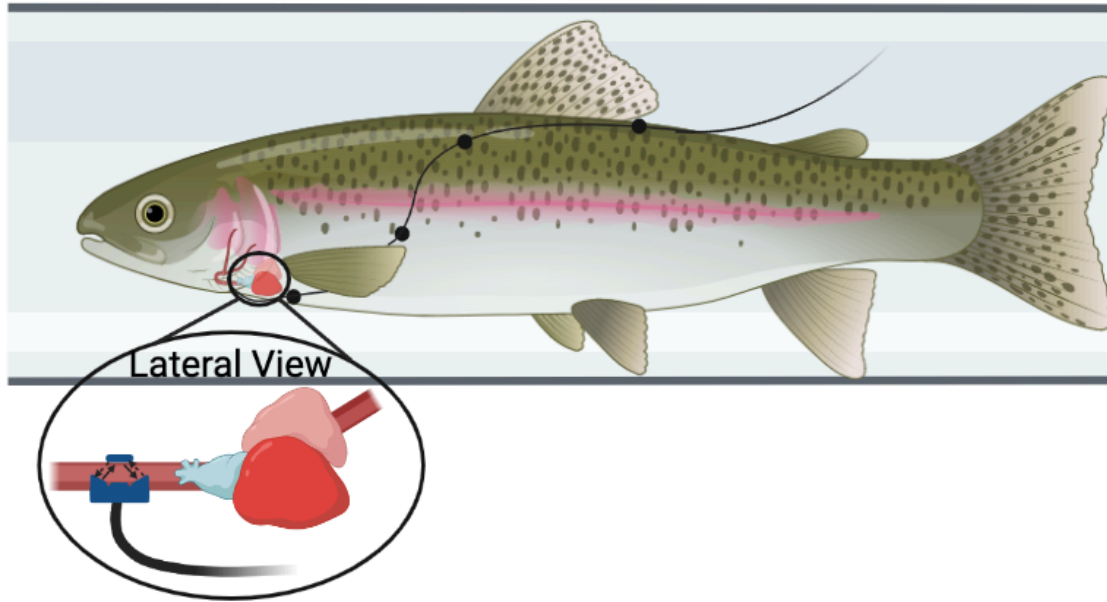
Flow probe and cable placement for ultrasonic flow probe measured cardiac output (\dot{Q}) and stroke volume (SV) of brook char (*Salvelinus fontinalis*) during acute hypoxia and reoxygenation. The enlarged portion depicts the location of probe placement on the ventral aorta, oriented to avoid blood flow restriction or dislodgement. Black dots represent the locations of the suture placement.
